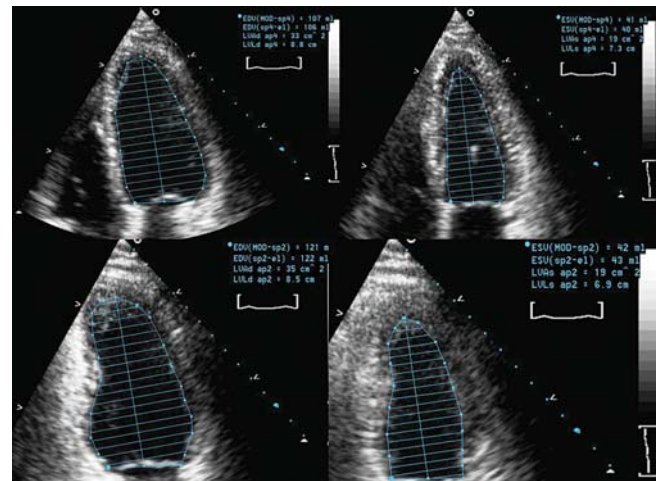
Apical 4 chamber (top panel) and 2 chamber (bottom panel) modified biplane method of discs measuring LV end diastolic and end systolic volumes.
